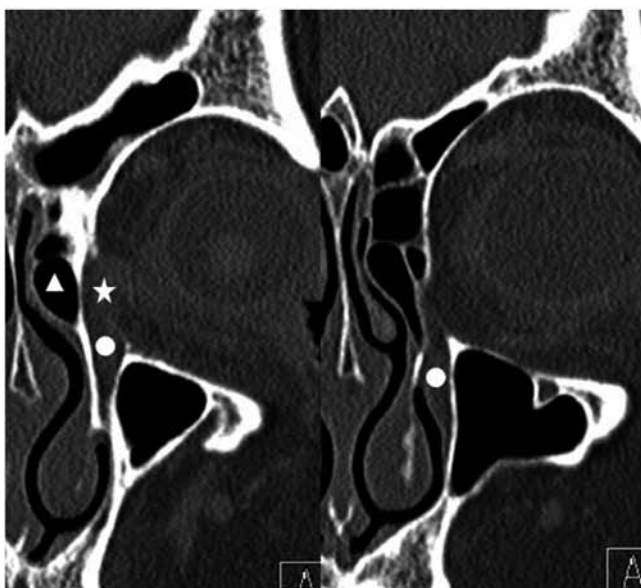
Coronal CT scans (sequence) showing the relation between agger nasi (white triangle), lacrimal sac (white star) and nasolacrimal duct (white circle).
